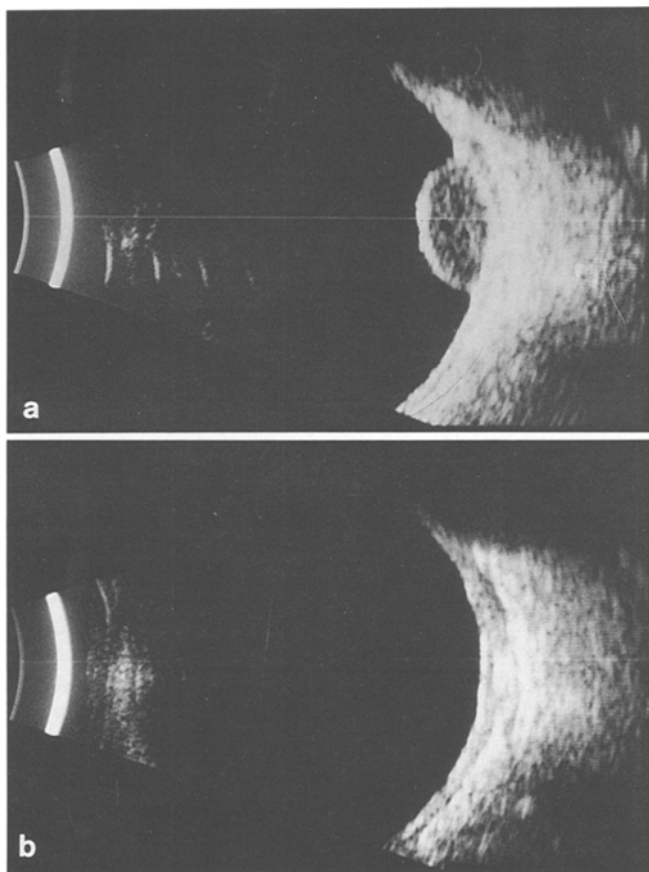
B-scan ultrasonography of choroidal melanoma treated by combined plaque-laser therapy (same case as shown in Fig. 2). a Pre-treatment cross-sectional appearance of nodular tumor. b Same location in fundus 18 months following start of treatment. No detectable tumor residue remains
